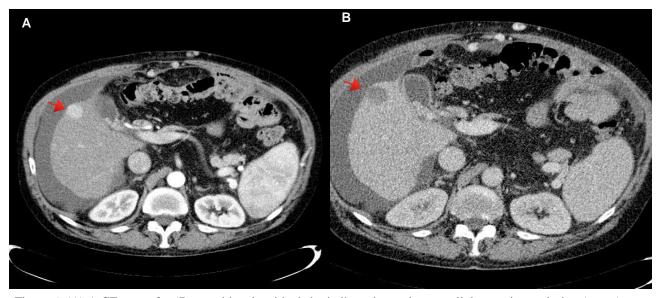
(A) A CT scan of a 67 year old male with cirrhotic liver show a hepatocellular carcinoma lesion (arrow). Dose of 30 ml ethanol was delivered in three injections to the tumor lesion over 8 days. (B) A control CT taken few days after the procedure shows tumor destruction. PEI can be repeated if viable tumor tissue is detected.
